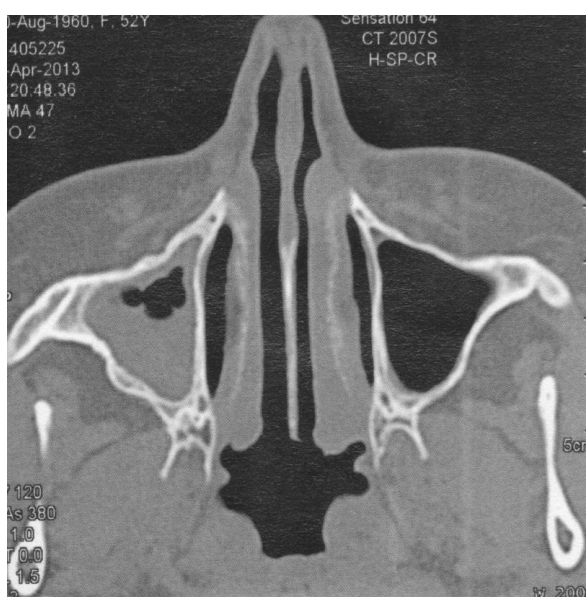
CT image. Native examination
